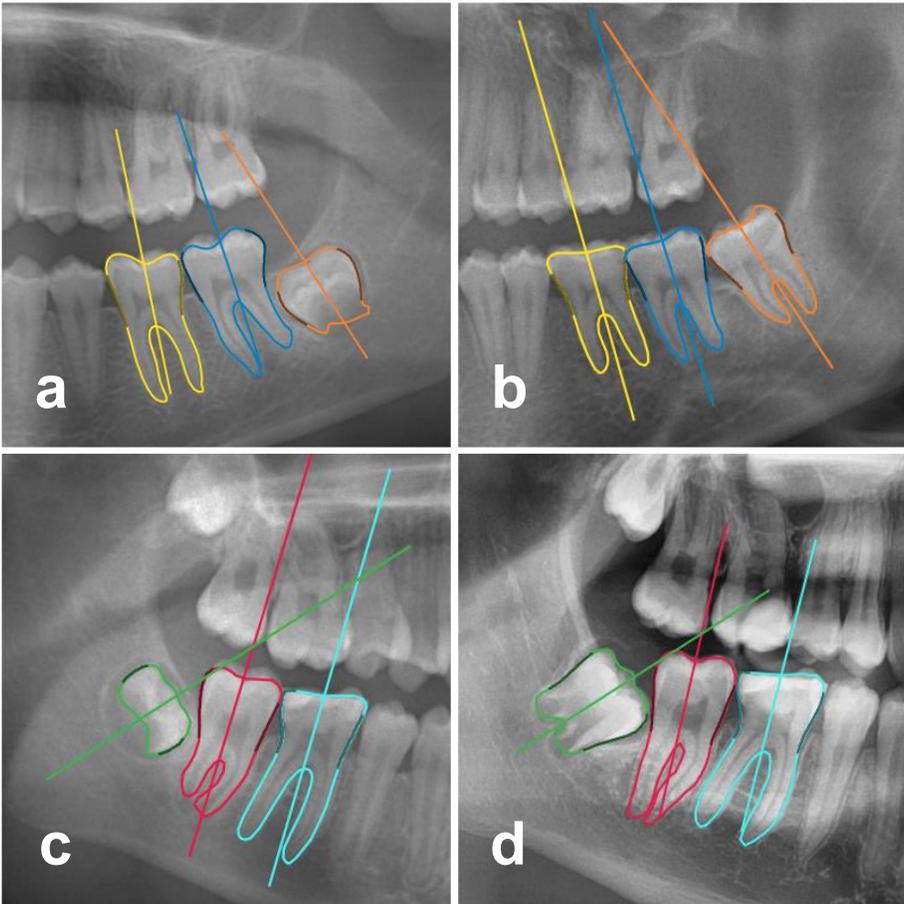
Consecutive panoramic radiographs with a 4-year interval showing third molar eruption in (a) and (b); and third molar impaction in (c) and (d).
